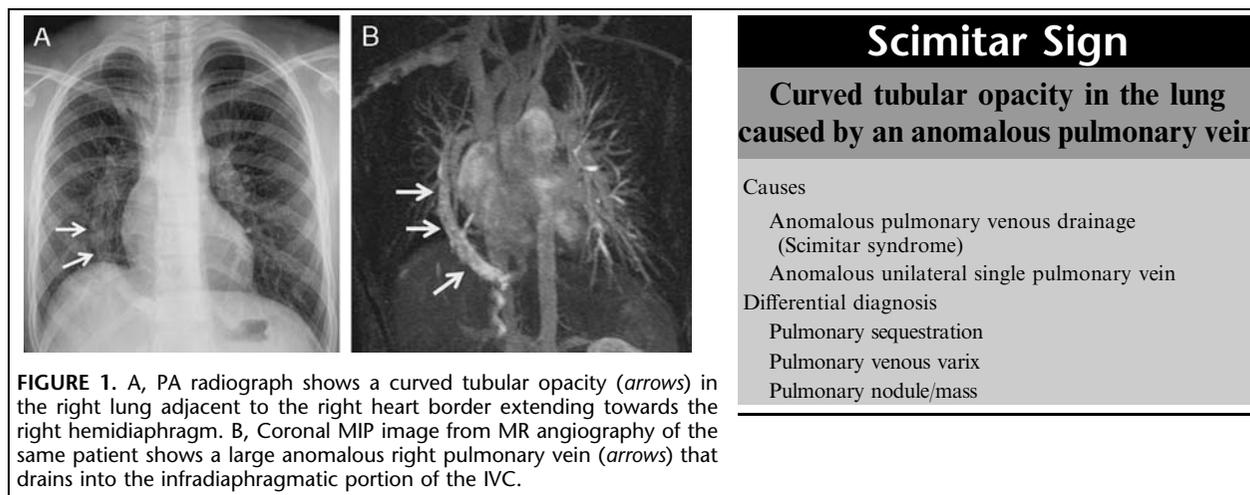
A, PA radiograph shows a curved tubular opacity (arrows) in the right lung adjacent to the right heart border extending towards the right hemidiaphragm. B, Coronal MIP image from MR angiography of the same patient shows a large anomalous right pulmonary vein (arrows) that drains into the infradiaphragmatic portion of the IVC.
